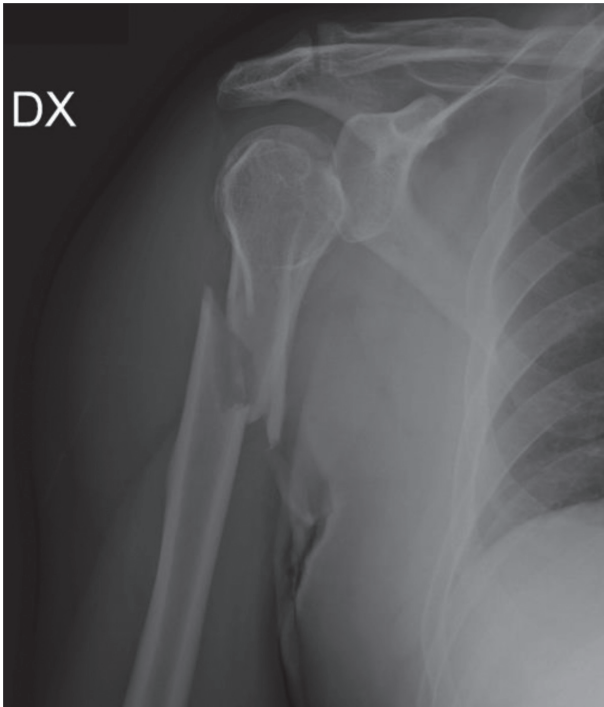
Preoperative X-ray (AP view - intrarotation)
